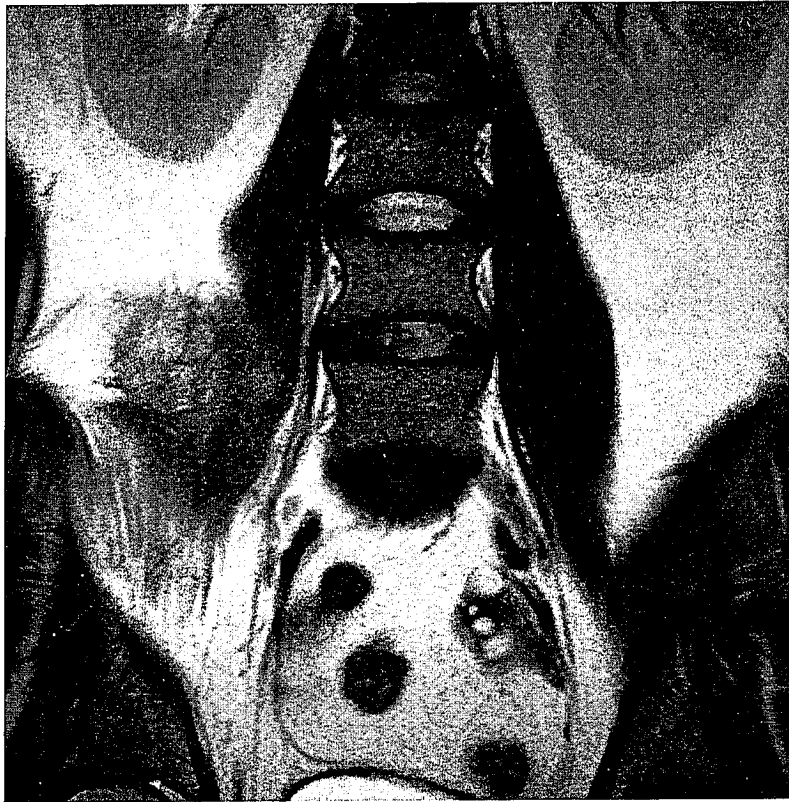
Abdominal MRI scan showing a poorly defined multiloculated right side mass in the m. psoas/lumbar quadratum area.
